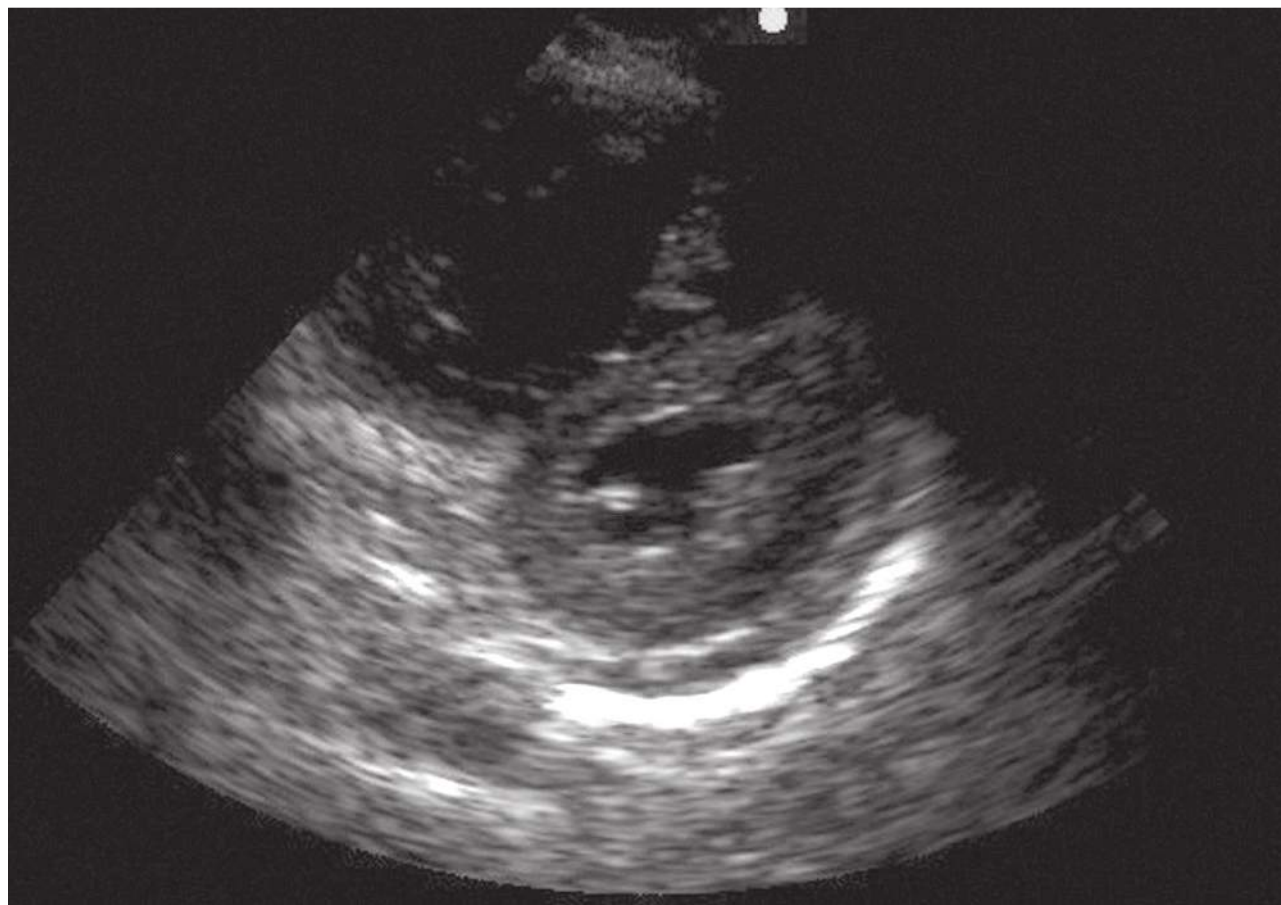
Parasternal short-axis view showing right ventricular dilation and septal shift. Note the characteristic D sign, with flattening of the septal wall during diastole secondary to increased right ventricular pressure. This gives the left ventricle a D shape, as opposed to its usual rounded O shape.
